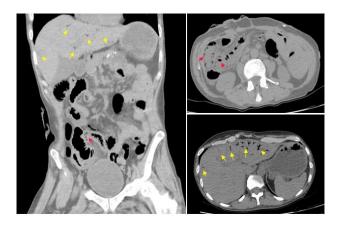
CT KUB shows pneumatosis intestinalis (red arrowheads) and gas within the portal system (yellow arrowheads) during the second admission with NOMI.
